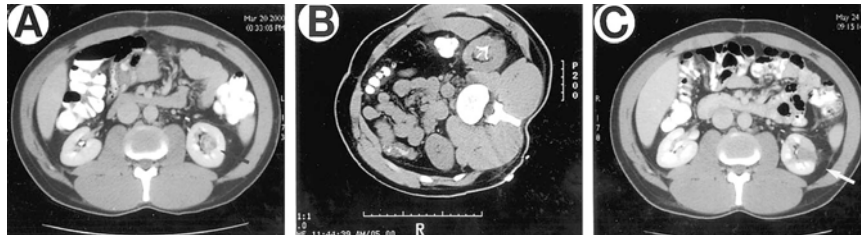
CT. *A*, day before radio frequency ablation (patient 7, treatment 8), with 2.2 cm. medullary tumor (black arrow) representing significant pretreatment enhancement (difference in HU 69). *B*, during radio frequency ablation. *C*, 2 months after radio frequency ablation. After treatment lesion has decreased in diameter to 1.6 cm. (white arrow) and lost contrast enhancement (difference in HU 4). Cauterized needle track is still visible 2 months after ablating central tumor (white arrow).
